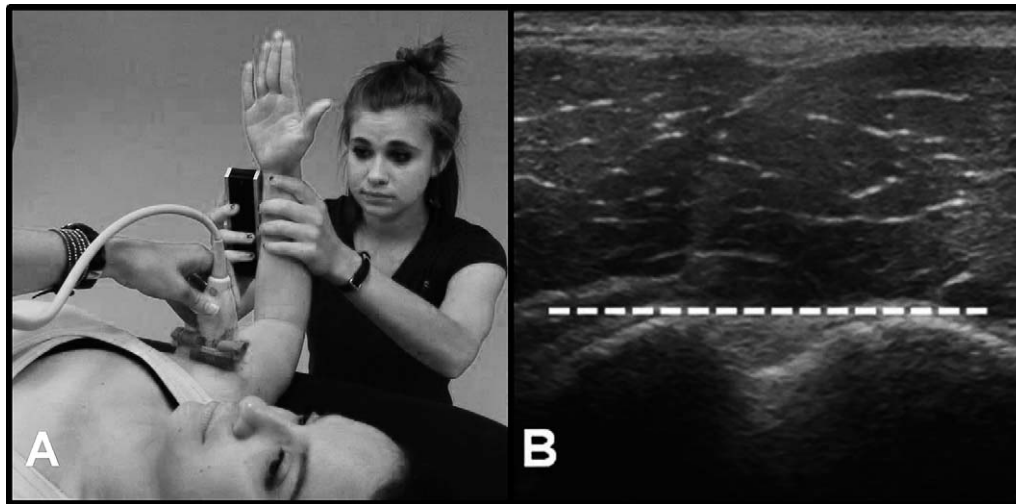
A, Ultrasonographic assessment of humeral retrotorsion. B, Ultrasonographic image of the upper humerus with the humeral tubercles pointing superiorly.
